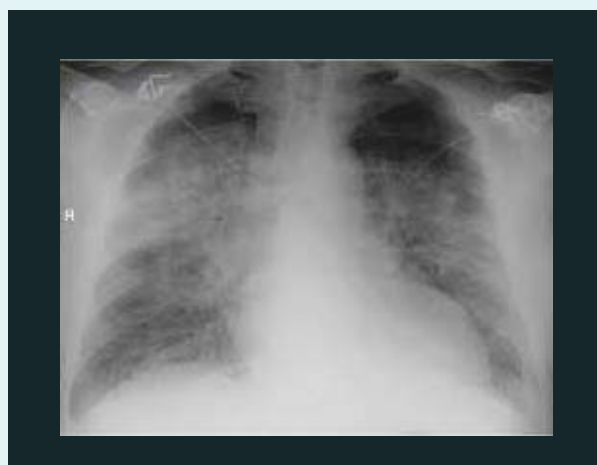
Posterior-anterior thoracic radiography at 72 hours from admission indicates the progression of reticulomonodular opacity compared to the previous radiological exam.
